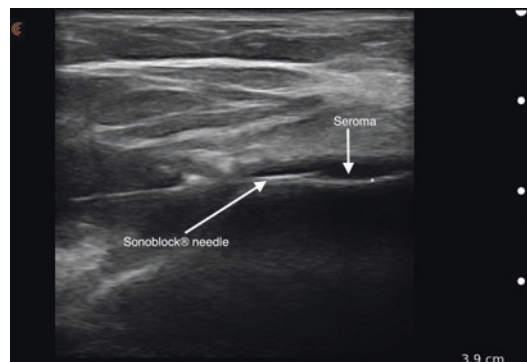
Grayscale ultrasound image of a breast implant seroma being aspirated with a needle. * denotes the elastomer shell of the breast implant
